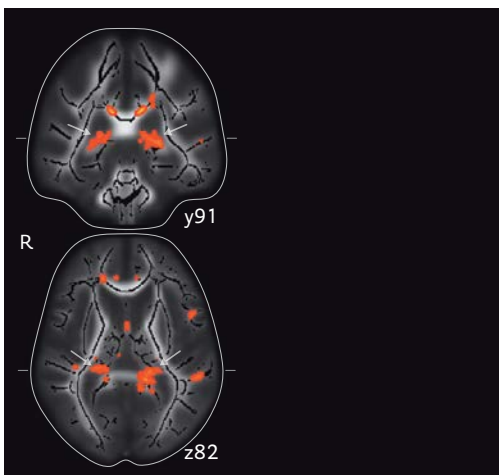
White matter lesions and reduced fractional anisotropy in periventricular regions. Coronal, sagittal and axial projections of mean fractional anisotropy (FA) MRI image on which the white matter skeleton (black) is projected. MNI coordinates are depicted for each projection. Normal-appearing white matter with reduced FA in relation to white matter lesions is visible in posterior periventricular regions (yellow-to-red colors).
